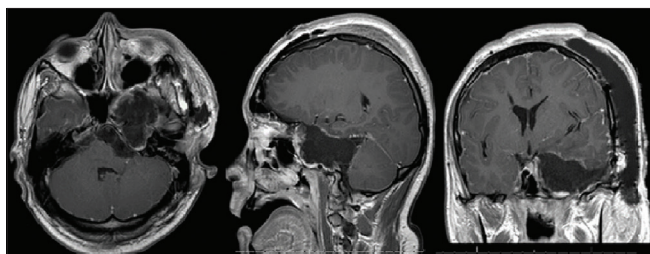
Postoperative magnetic resonance imaging figure description: contrasted T1-weighted magnetic resonance imaging with axial, sagittal, and coronal views demonstrates near complete resection with a thin rim of residual tumor along the lateral dural margin of the left cavernous sinus/lesser sphenoid wing and at the floor of the left middle cranial fossa extending posteriorly to the roof of the remodeled left petrous temporal bone.
